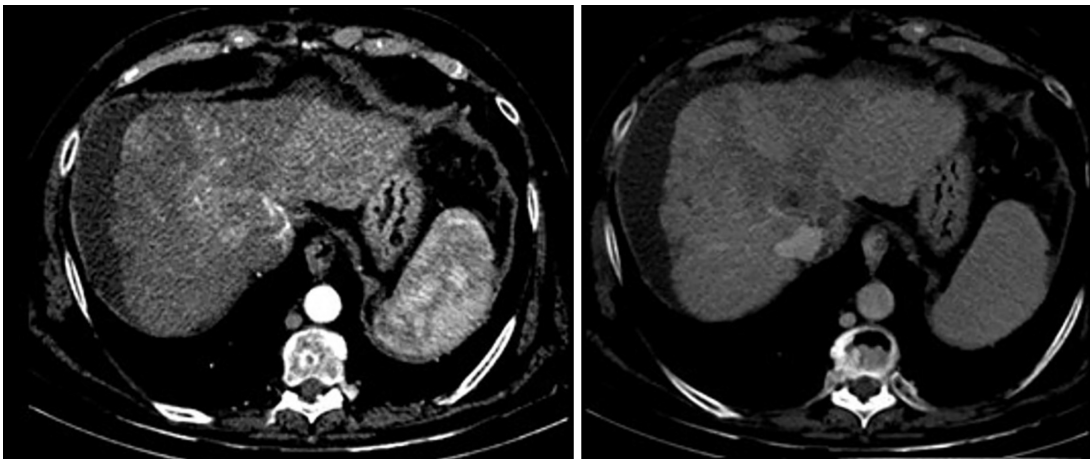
Computed tomography scan axial view shows a poorly defined liver injury with margins of 55 mm × 90 mm located in segment VIII and with extension to segment V and segment I, enhanced in arterial phase with fast venous phase washing.
